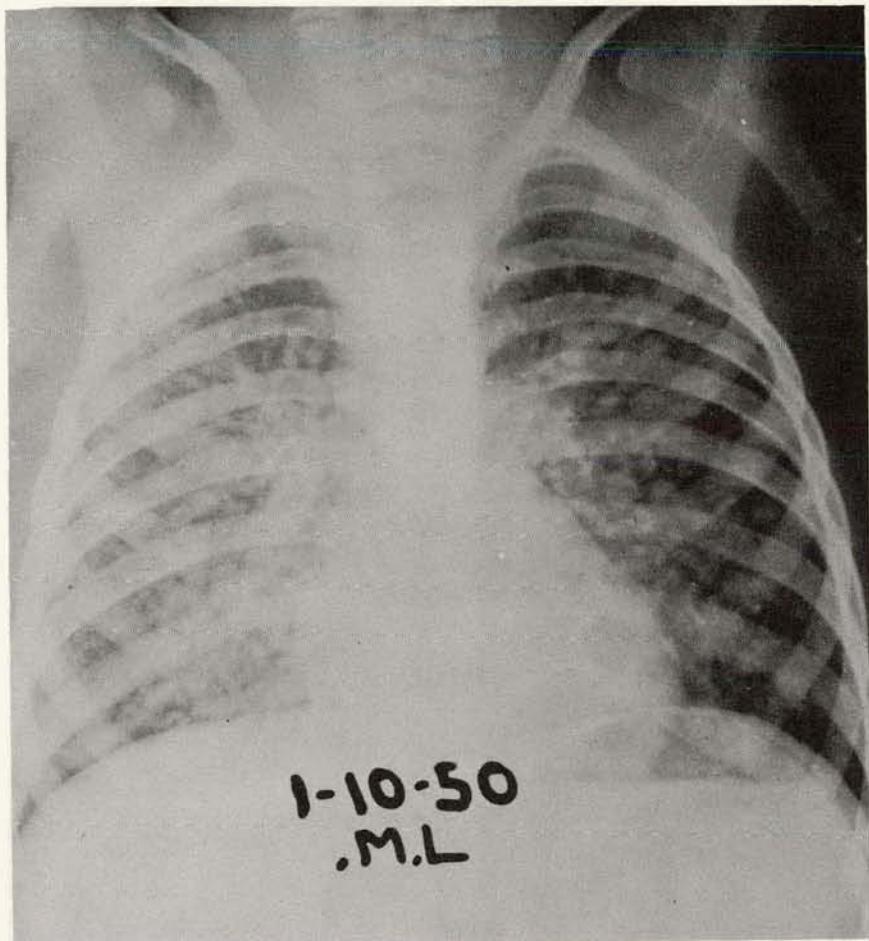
Roentgenograph of the chest of a 4-year-old boy showing extensive miliary type metastases throughout both lungs.
